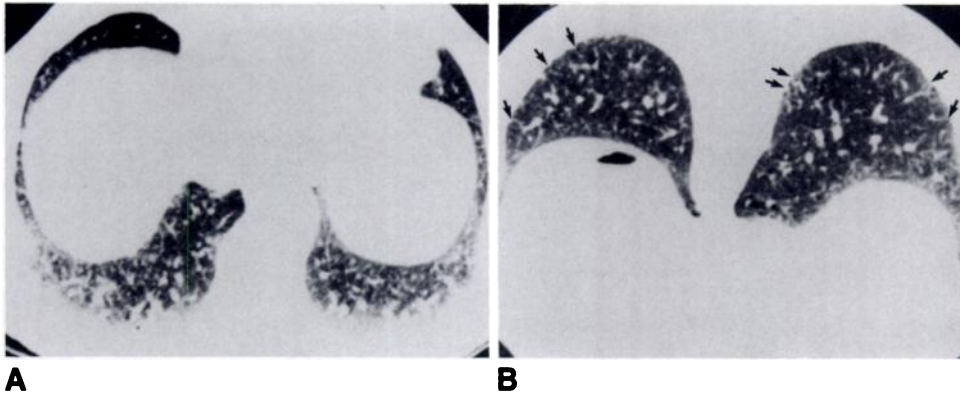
High-resolution CT of dependent density and septal thickening. A, Scan with subject supine shows dependent density posteriorly, obscuring underlying lung morphology. B, Scan with subject prone shows clearing of dependent density. Numerous thickened interstitial short lines (arrows) are visible. Vascular distension would resolve in prone position.
